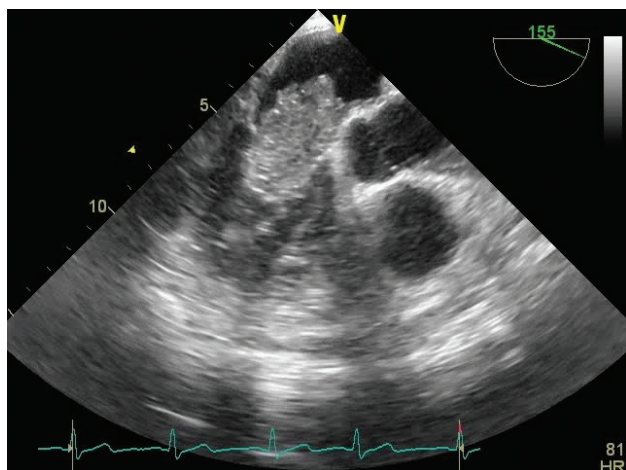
A transesophageal echocardiogram – polypoid cardiac mass in the left atrium, which protrude into the left ventricle depending on the phase of the cardiac cycle.
